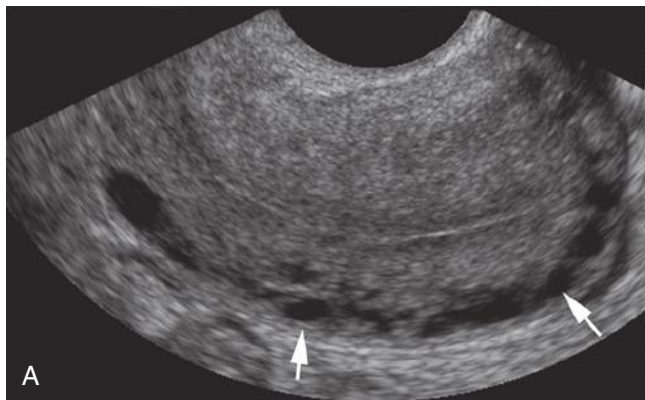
Prominent vessels (*arrows*) at the periphery of the uterus are common in the uterus and should not be mistaken as a precursor to an abruption or as trophoblastic disease. A, In this patient, the arcuate vessels (*arrows*) at the periphery of the uterus are quite prominent. B, With color Doppler flow imaging, the vascular nature of these structures is well seen.
